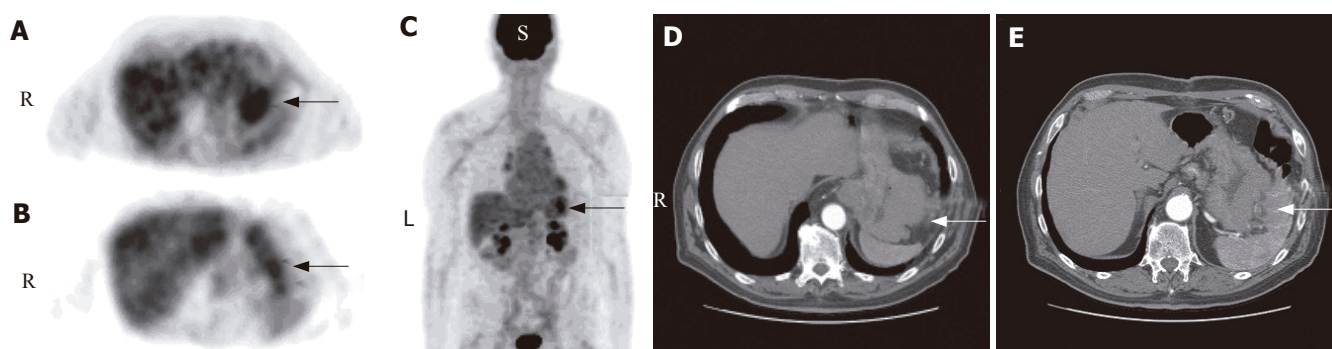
An 80-year-old man with MALT-type lymphoma. A-C: ^{18}F -FDG PET scans in transaxial and projection images showed a focal mild hypermetabolic activity ($\text{SUV}_{\text{max}} = 3.8$) in the region of stomach (black arrow); D and E: CT scans showed a bulky mass in the wall of gastric fundus and body (white arrow).
